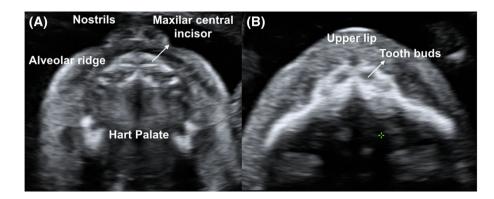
Normal fetus two-dimensional (2-D) ultrasound image of the maxilla at 22 weeks gestation. To obtain a better visualization, the fetal head must be deflected. The maxilla appears as a regular, U-shaped echoic structure (A). The alveolus and tooth buds appears hypoechoic regularly layered along the alveolar ridge (B). In the anterior part appears the maxillary central incisors. The anterior part of the hard palate is semicircular and lies immediately posterior to the alveolar ridge [Colour figure can be viewed at wileyonlinelibrary.com]
